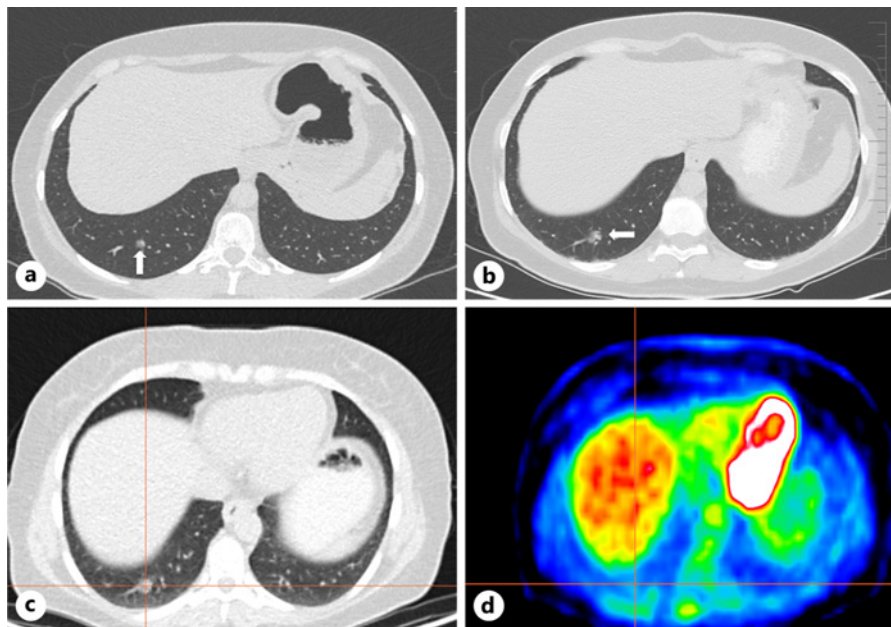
a Axial CT scan from November 2017 with a small pure ground glass nodule. b The control axial CT scan from June 2020 shows a change in the nature of the lesion to a subsolid nodule with a solid component. c, d The PET/CT examination from July 2020 demonstrates the persistence of the deposit without its metabolic activity.
